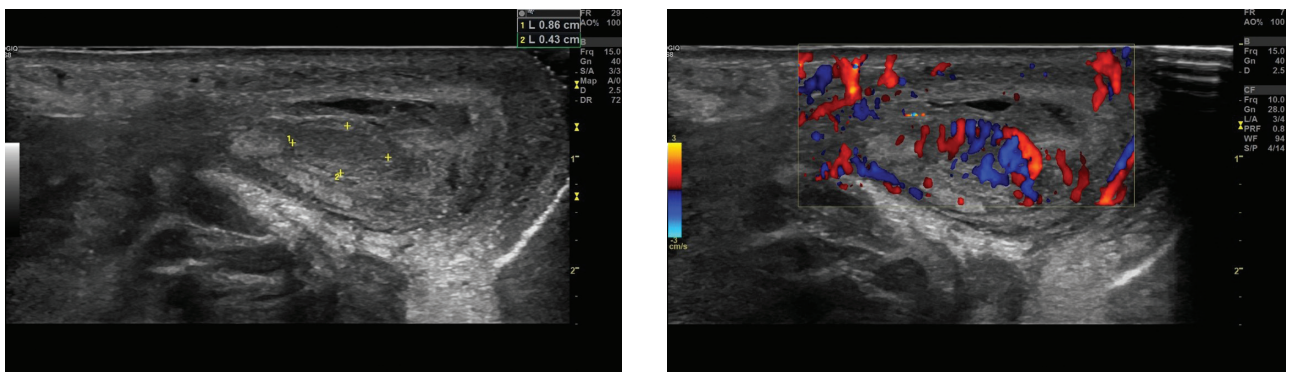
Longitudinal view of the scrotum. a. Gray-scale US. b. Colour Doppler US.
